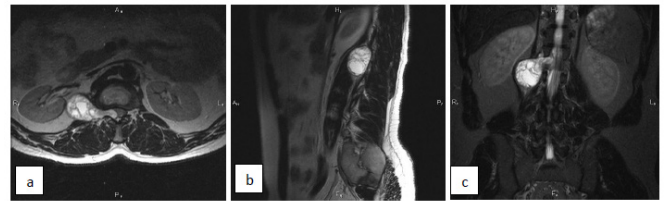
On the T1 post-contrast axial (a), sagittal (b), and coronal (c) MRI sequences, we notice a well-demarcated intraspinal mass, with mixed hyperintense contrast enhancement and visible hypointense septations, close to the right neural root, measuring 64x40 mm, suggestive of a lumbar dumbbell schwannoma. The coronal view demonstrates its proximity to the spinal canal, highlighting its spatial relationship to surrounding structures.
